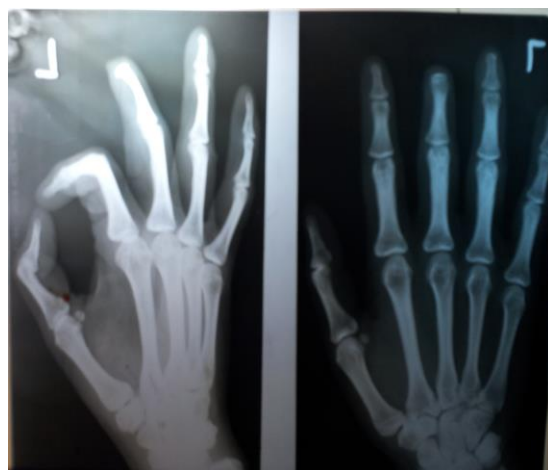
Pre-operative radiograph of hand
